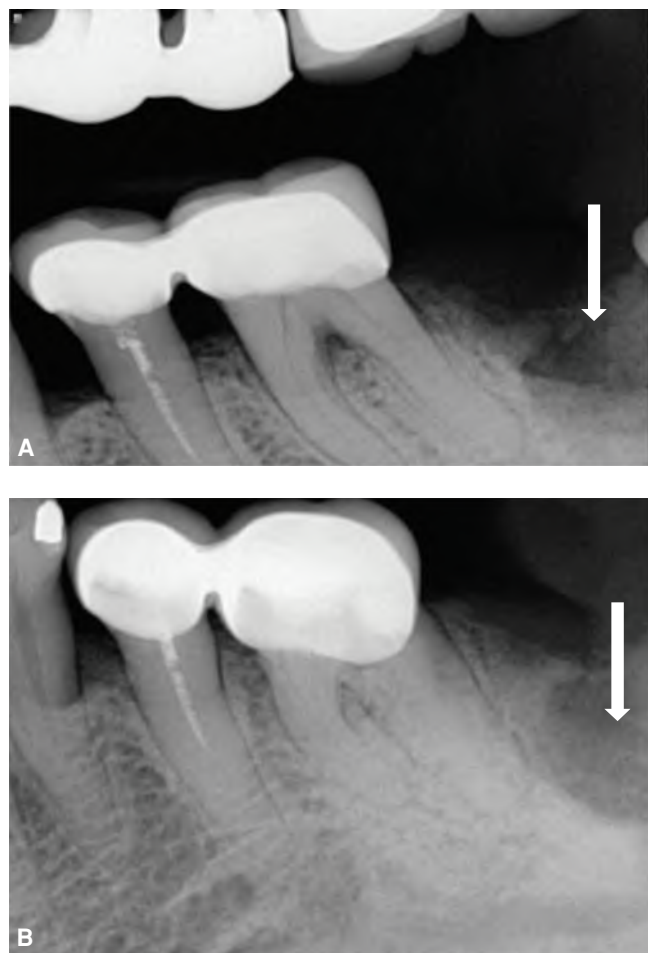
Pain mimicking endodontic symptoms in a 83-year-old female with osteonecrosis of the jaw (ONJ). The patient was referred for root canal treatment in the mandibular left first molar. Both the mandibular left first molar and second premolar were asymptomatic and responded normally to pulp testing. The patient has been receiving medical treatment for ONJ that developed after extraction of the mandibular left second molar. A. Preoperative bitewing radiograph and B. Preoperative periapical radiograph showing area of osteonecrosis in the lower left mandible.
